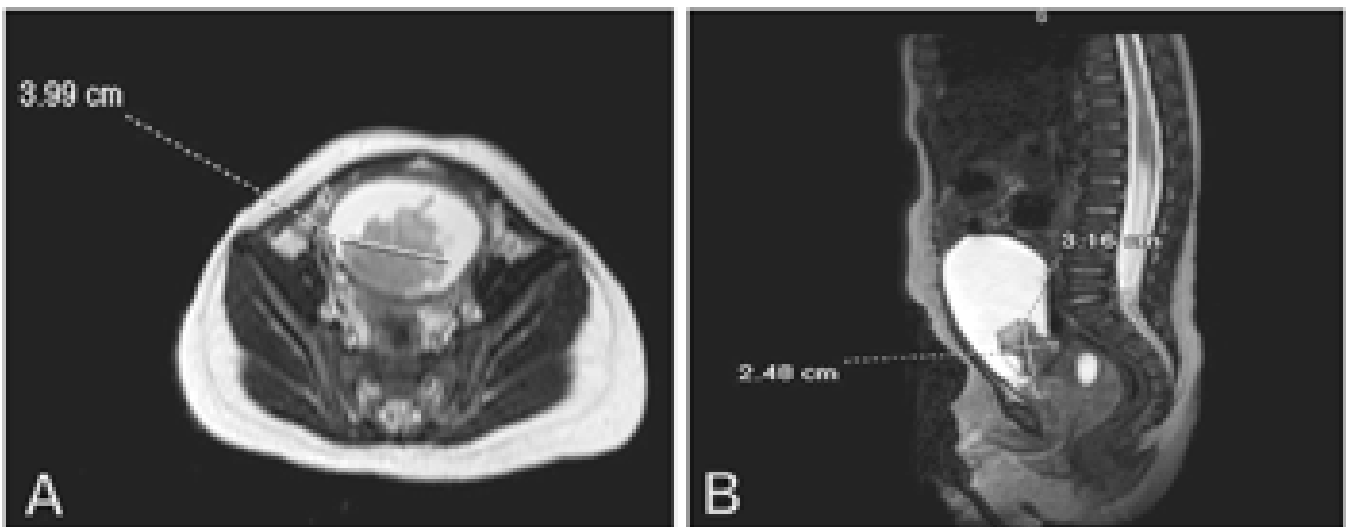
Non-contrast abdominal MRI. A (Transverse view) & B (Sagittal view). Intravesical component, in the inferior aspect of the urinary bladder, measuring about 3.2cm x 2.5cm x 4.0cm.
